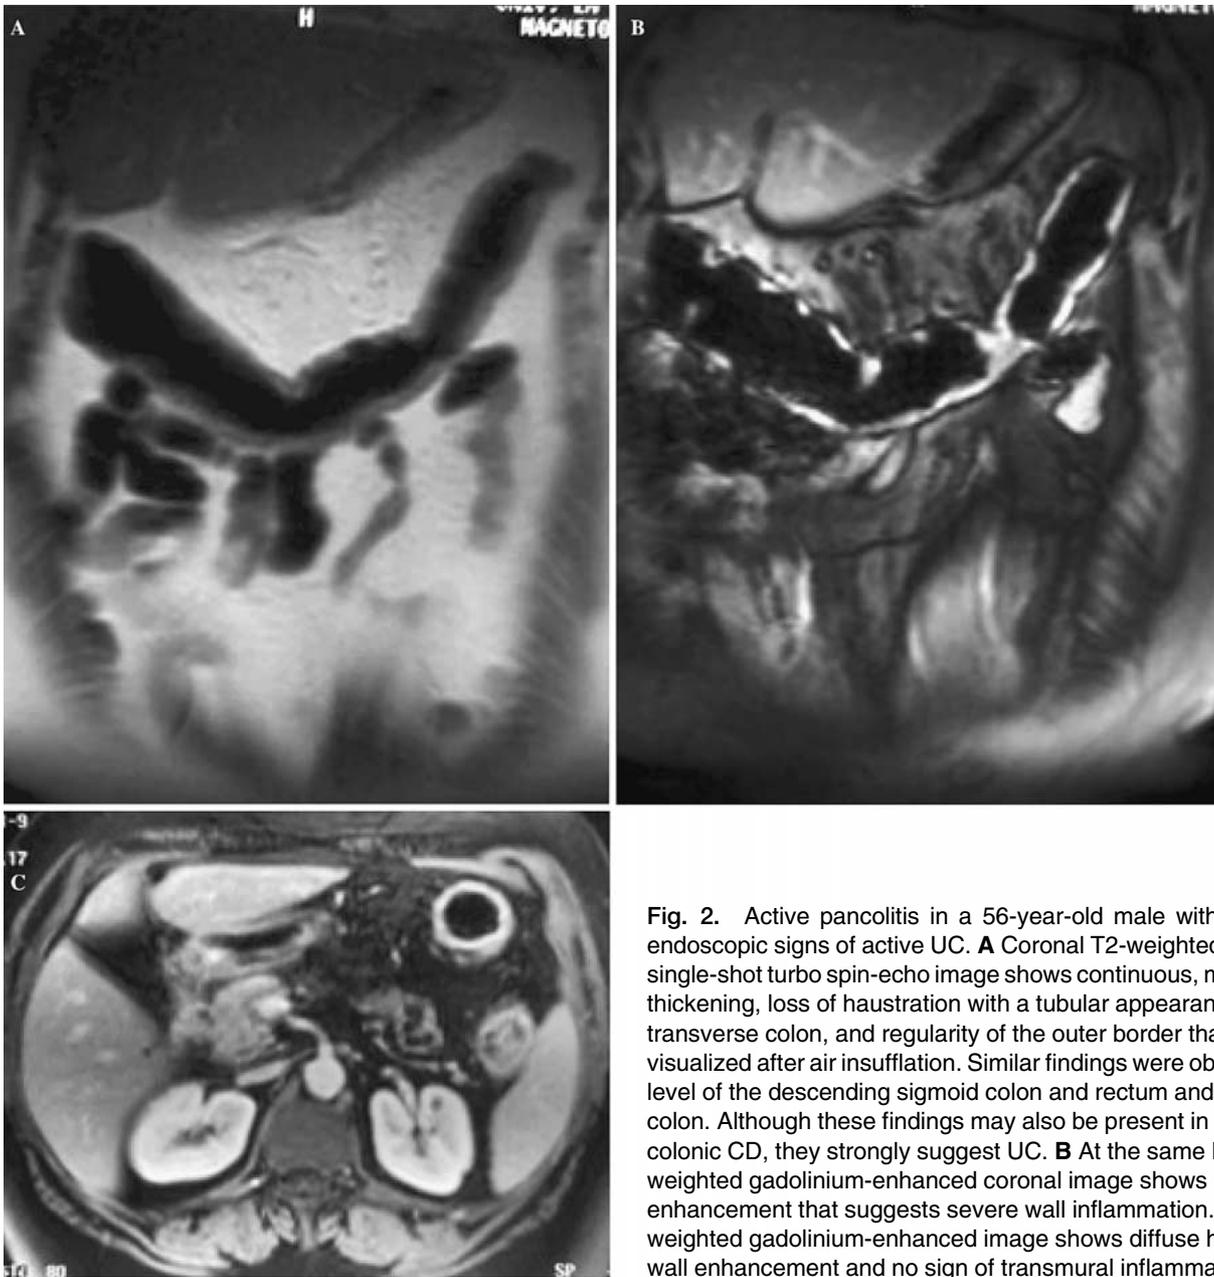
Active pancolitis in a 56-year-old male with clinical and endoscopic signs of active UC. A Coronal T2-weighted half-Fourier single-shot turbo spin-echo image shows continuous, moderate wall thickening, loss of haustration with a tubular appearance of the transverse colon, and regularity of the outer border that is clearly visualized after air insufflation. Similar findings were observed at the level of the descending sigmoid colon and rectum and of the right colon. Although these findings may also be present in longstanding colonic CD, they strongly suggest UC. B At the same level, T1-weighted gadolinium-enhanced coronal image shows diffuse wall enhancement that suggests severe wall inflammation. C Axial T1-weighted gadolinium-enhanced image shows diffuse high-grade wall enhancement and no sign of transmural inflammation.
